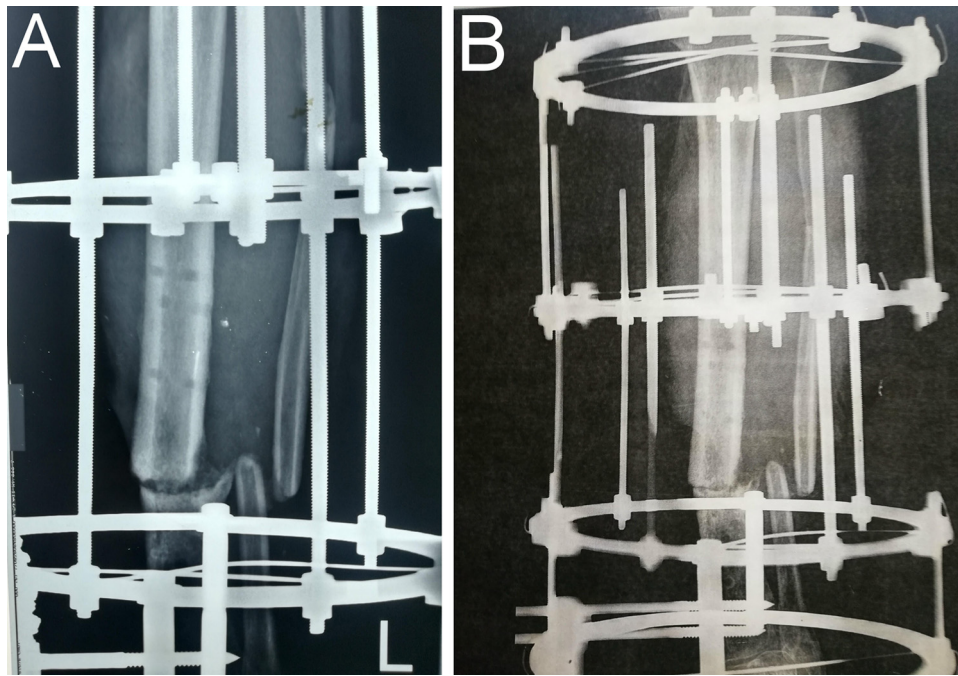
A. Plane X-ray antero-posterior view shows cycle of distraction. B. Plane X-ray Antero-posterior view shows the cycle of compression.
